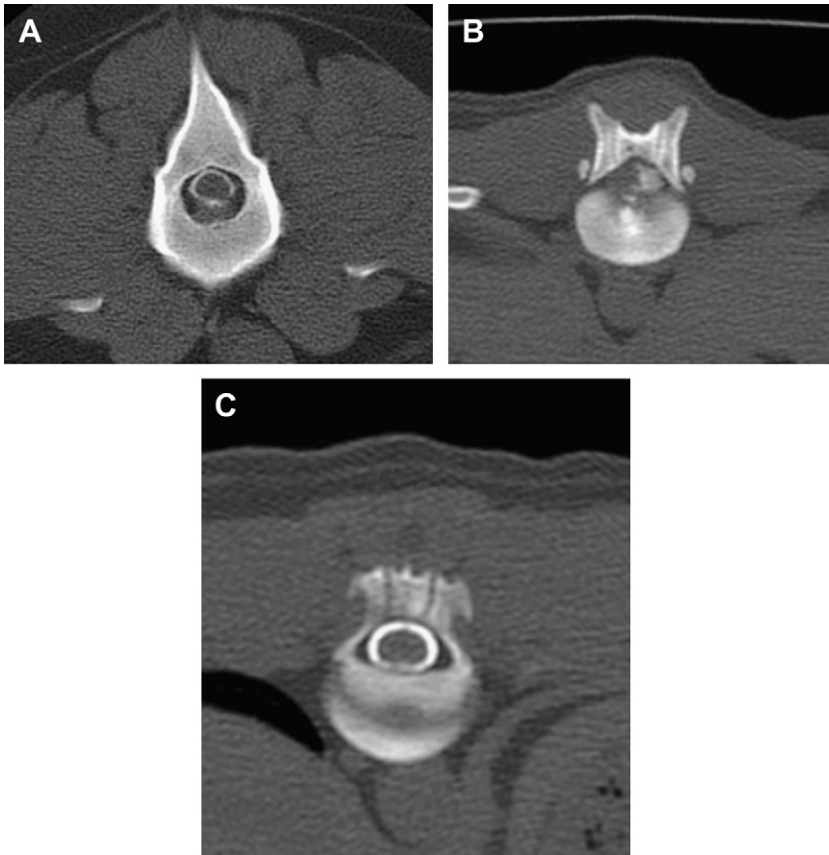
CT image of a soft (nonmineralized) disc extrusion (A), mineralized disc extrusion (B), and a normal CT myelogram (C).
